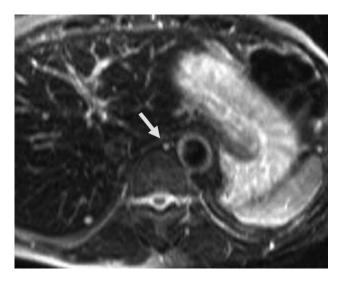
T2-weighted MR image (TR/TE = 3800/93) shows the normal cisterna chyli (arrow) with high signal intensity in the retrocrural space.
